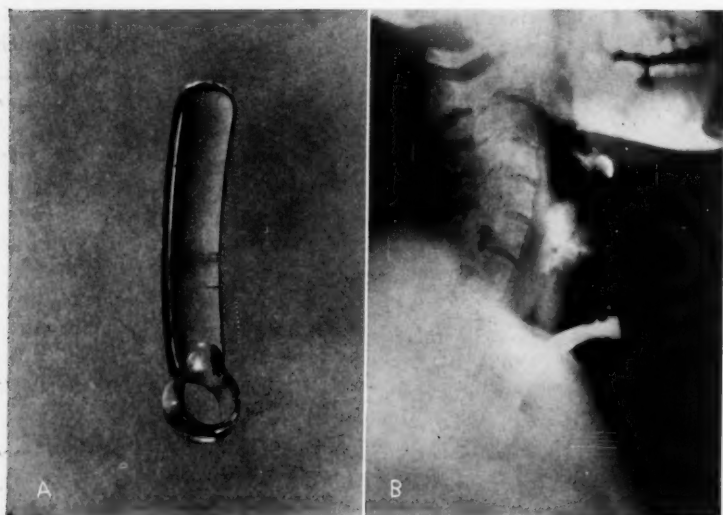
A. Acrylic laryngeal obturator with opening for tracheotomy tube. B. Lateral x-ray of the neck showing obturator in place. Tracheotomy tube passed through the opening holds it in place.
